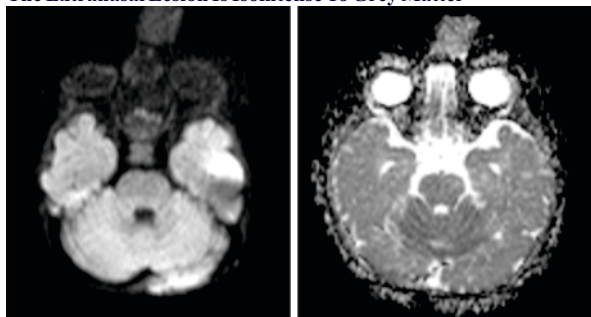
And 4b – DWI And ADC Images Showing No Diffusion Restriction
